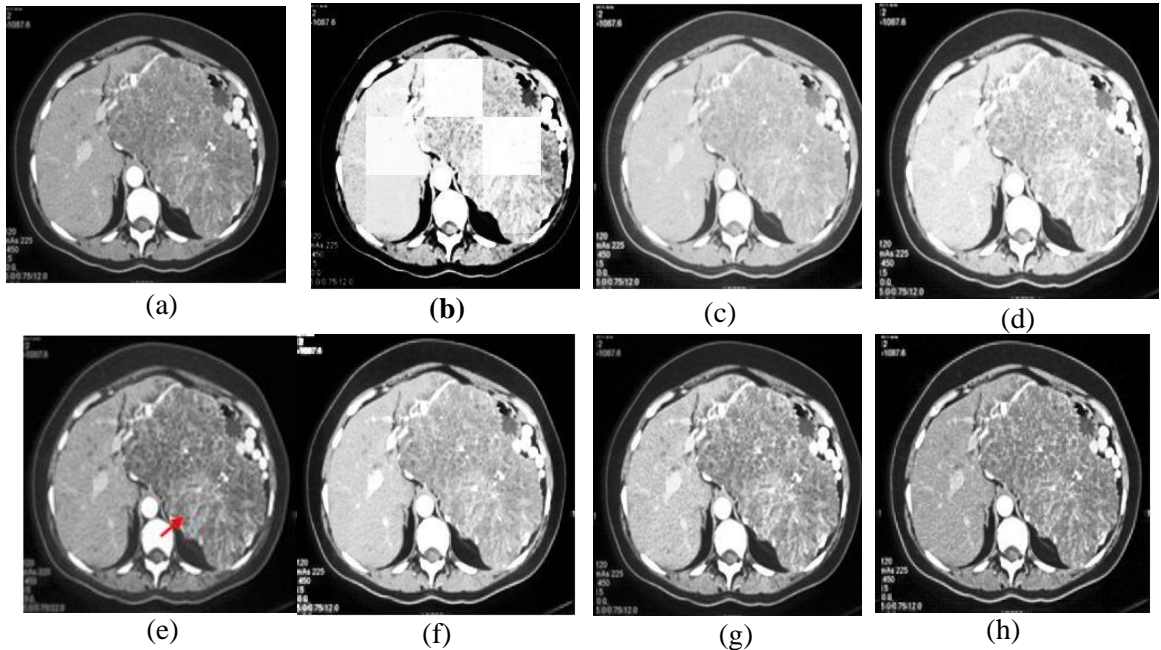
3.5 Input "CT-2" image and it's associated enhanced images (a) Input image, (b) S-curve, (c) AGC-DWT, (d) AGC-WHD, (e) GAGC-DWT, (f) EBCHE, (g) TCHE-DWT, (h) Proposed technique
